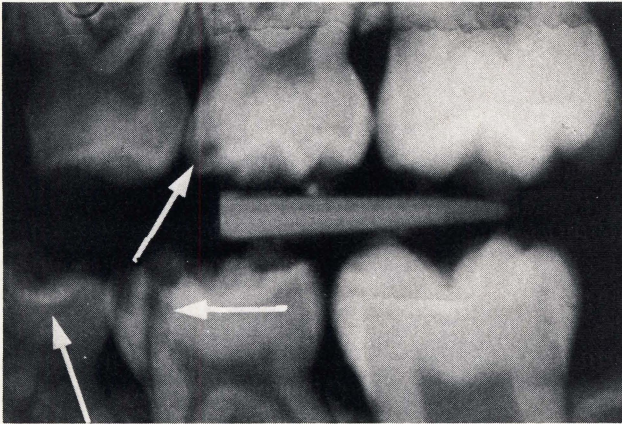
Left bitewing radiographs with arrows indicating the fracture lines of the maxillary left second primary molar, the mandibular left first primary molar and the mandibular left second primary molar.
